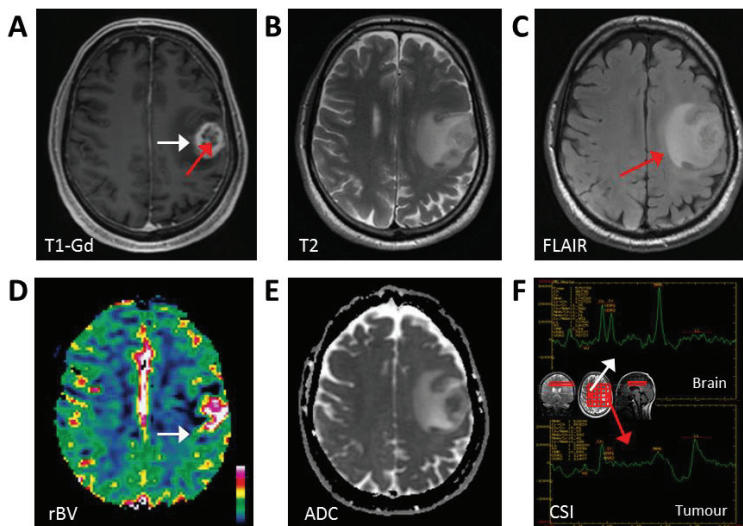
Multiparametric assessment of brain tumors with MRI
